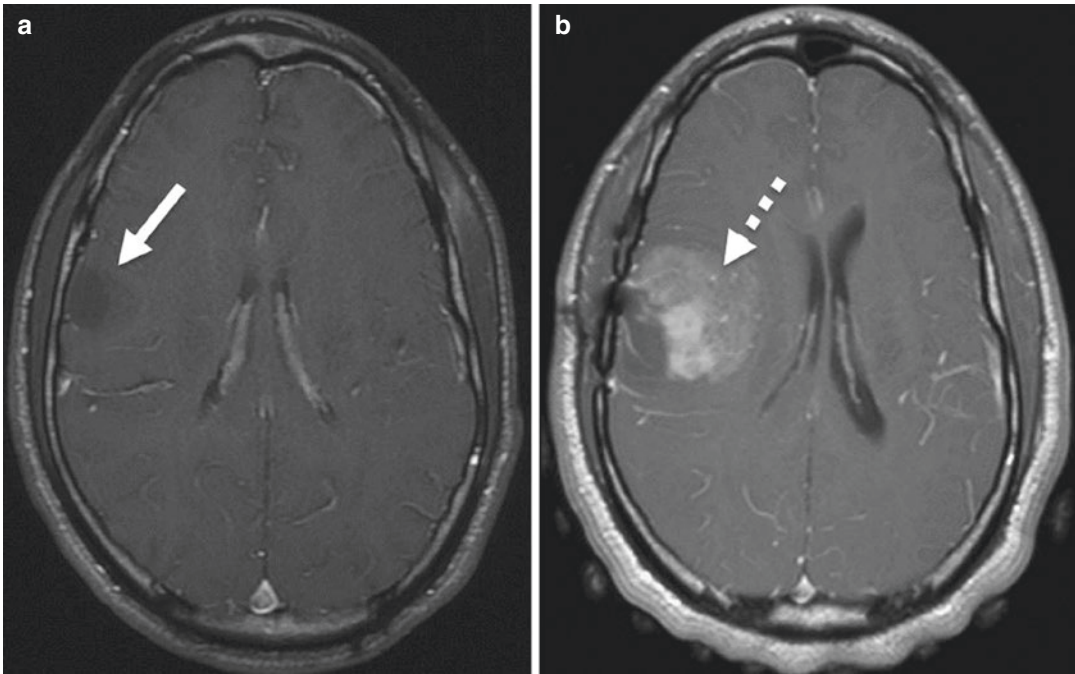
Tumor progression. (a) Preoperative contrast T1-weighted image demonstrates a small non-enhancing mass (arrow) with pathology showing grade II diffuse astrocytoma. (b) Follow-up contrast T1-weighted image
